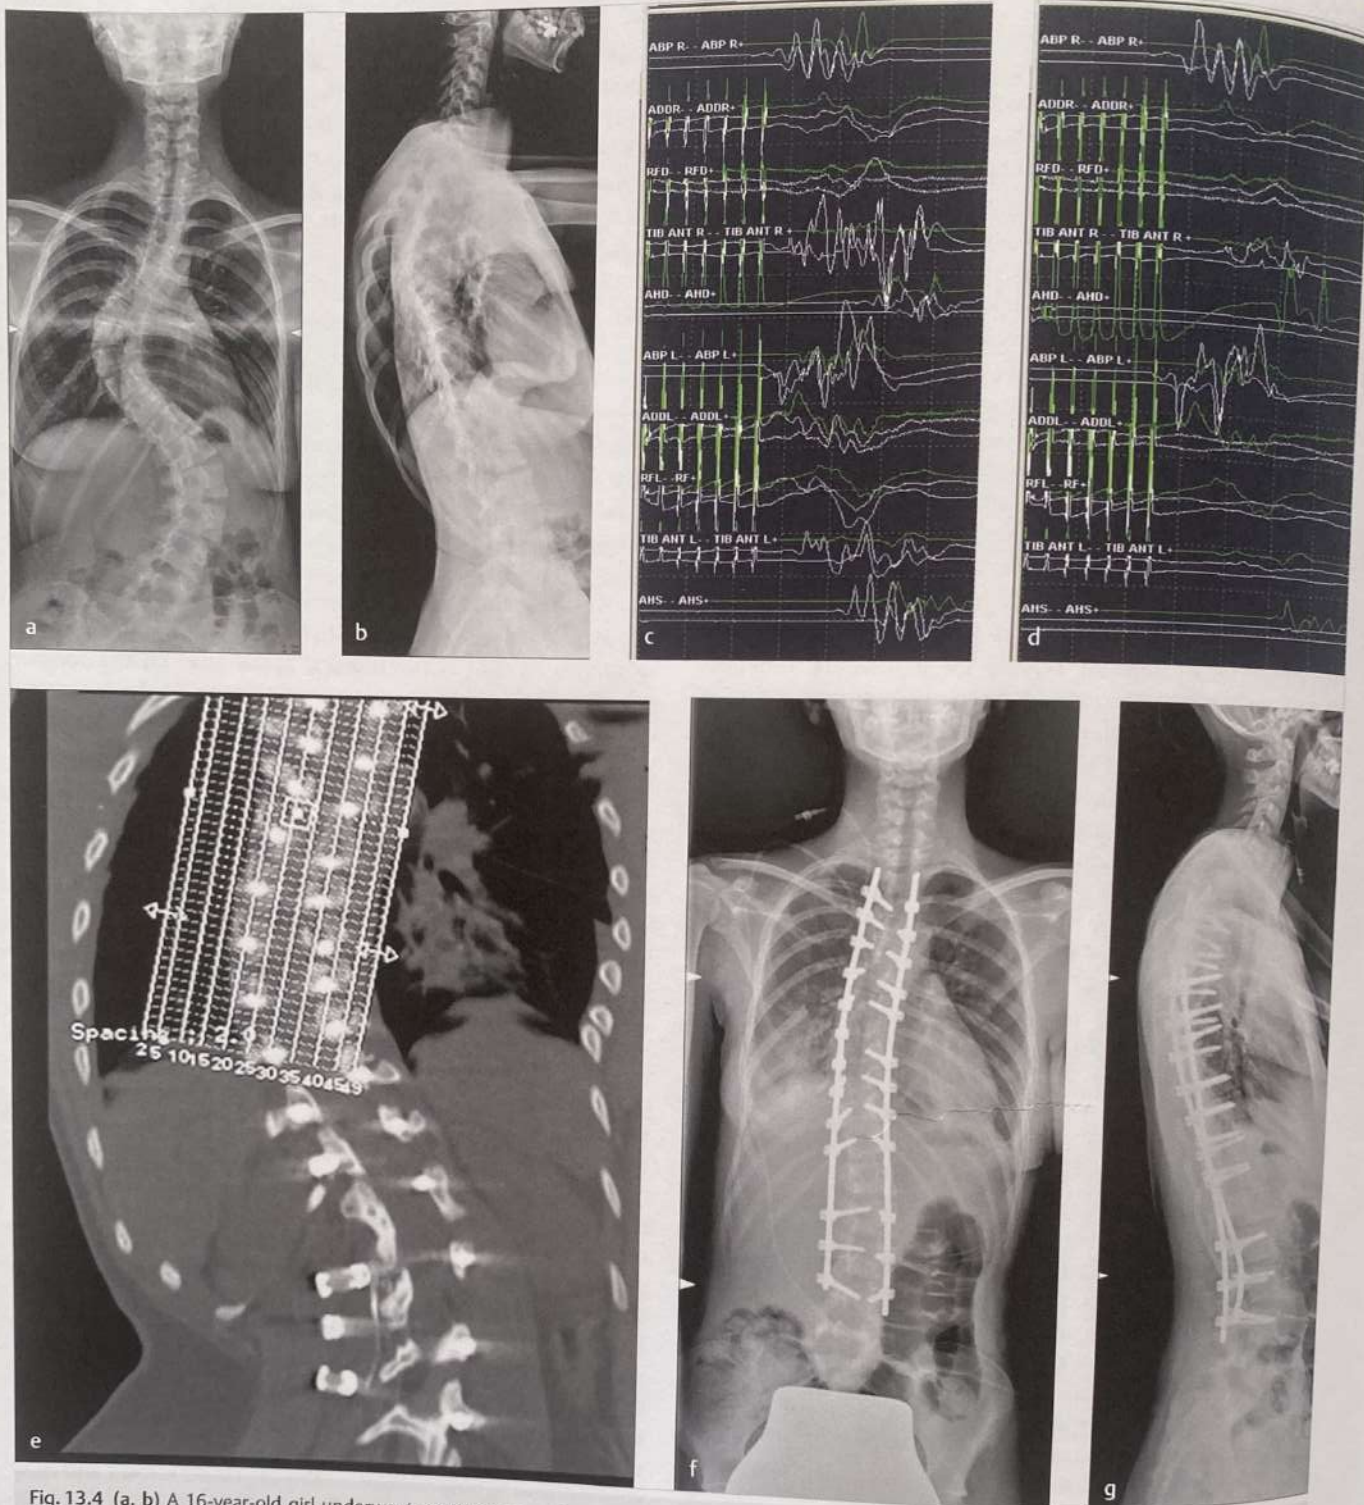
(a, b) A 16-year-old girl underwent posterior correction without having undergone prior halo-traction. (c, d) Intraoperatively, there was a persistent and severe reduction in amplitude of somatosensory and motor-evoked potentials after scoliosis correction. The rods were removed immediately. The wake-up test resulted in a return to normal, and there was no deficit at the end of surgery. The screws were removed and the rods were left inside. (e) CT scan done on the postoperative day confirmed the correct placement of the screws. (f, g) After a week a new surgery was performed for definitive correction without problems.
